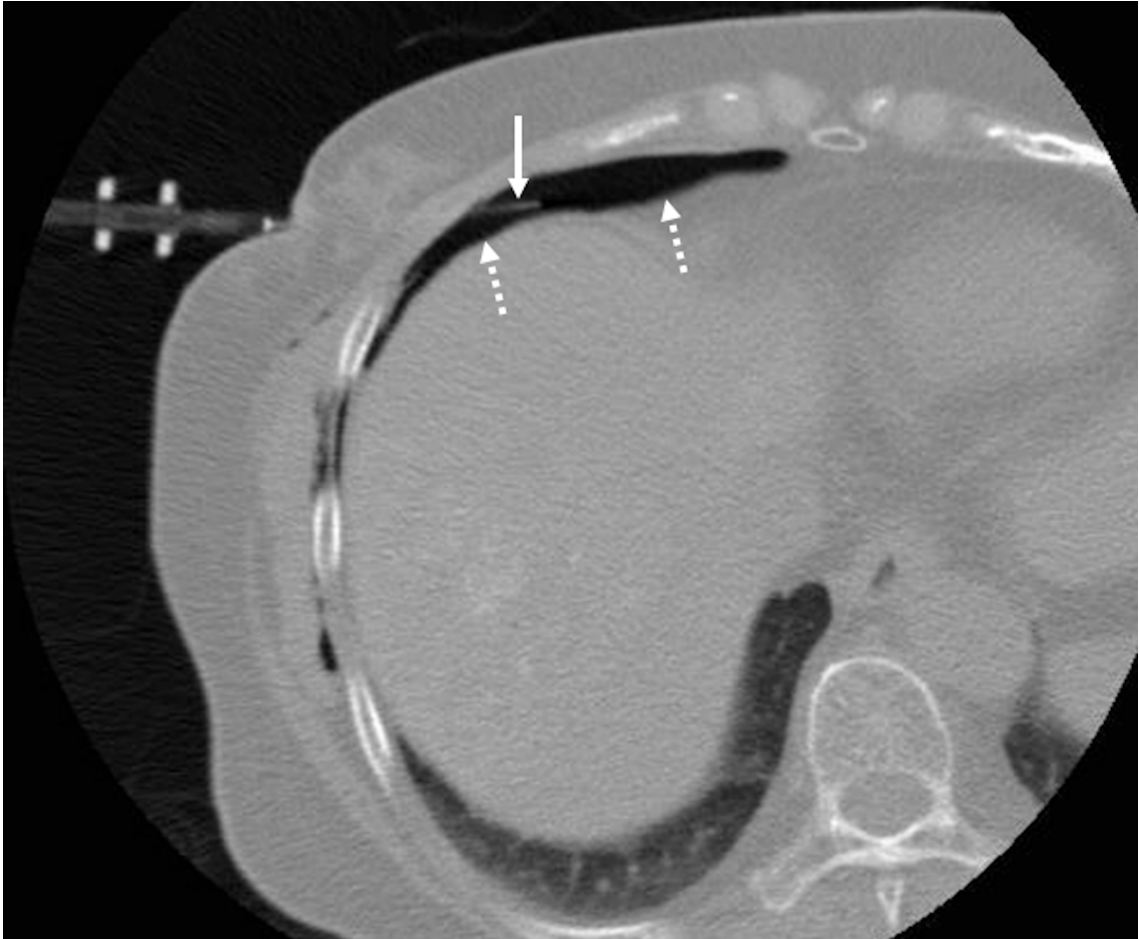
Artificial carbon dioxide (CO₂) pneumothorax induction with the two-step method: (a) An 18-gauge sheathed needle (arrow) is introduced into the liver surface at the lower end of the thoracic cavity with no intervening lung tissue under computed tomography (CT) fluoroscopic guidance. A small amount of CO₂ is injected. (b) Another 18-gauge sheathed needle (arrow) is introduced into the created intrapleural space (dashed arrows). (c) A radiofrequency (RF) electrode (arrowhead) is inserted into the target tumor (arrow) through the created intrapleural space (dashed arrows). (d) Contrast-enhanced CT obtained immediately after RF ablation shows a non-enhancing area (dashed arrows) surrounding the target tumor (arrow) with dense Lipiodol accumulation
